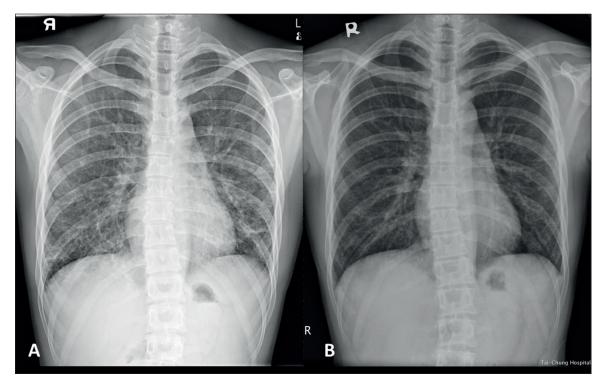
(A) Chest roentgenography revealed bilateral interstitial infiltration of lung fields on Day 1. (B) Chest roentgenography revealed significant improvement on Day 21.
